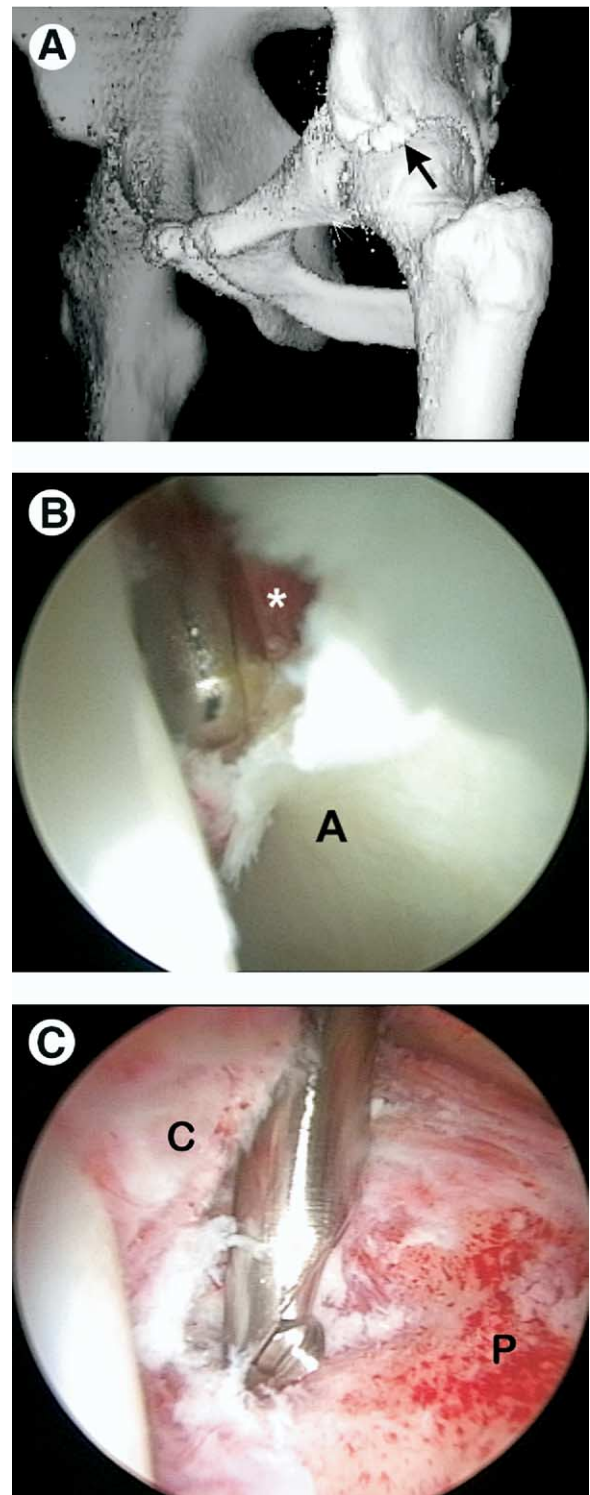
An 18-year-old high school football player sustained an avulsion fracture of the left anterior inferior iliac spine. (A) A 3-dimensional computed tomography scan shows the avulsed fragment (arrow), which ossified, creating an impinging painful block to flexion and internal rotation. (B) Viewing from the anterolateral portal, a capsular window is created, exposing the osteophyte (asterisk) anterior to the acetabulum (A). (C) The anterior capsule (C) has been completely released allowing resection of the fragment along the anterior column of the pelvis (P). Postoperatively, the patient regained full range of motion with resolution of his pain. (Figure © J.W. Thomas Byrd.) (Color version of figure is available online.)
